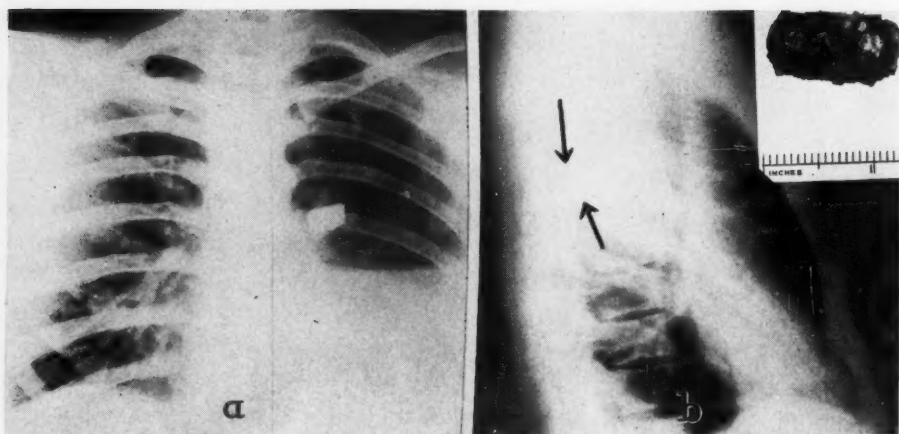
Case 10: Roentgenograms showing site of foreign body imbedded in lung. Insert shows fragment of shrapnel removed.
